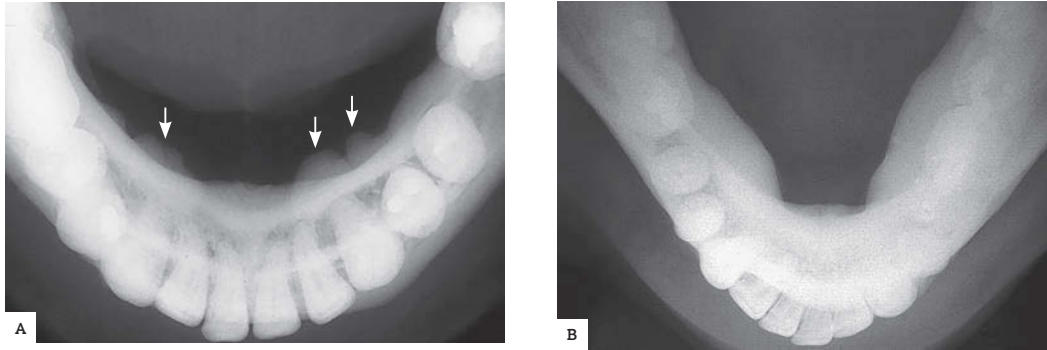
Radiographic images of nodular tori mandibularis on both sides of the jaws: A) multiple protuberances; B) wider basal bone in the mesiodistal plane.
